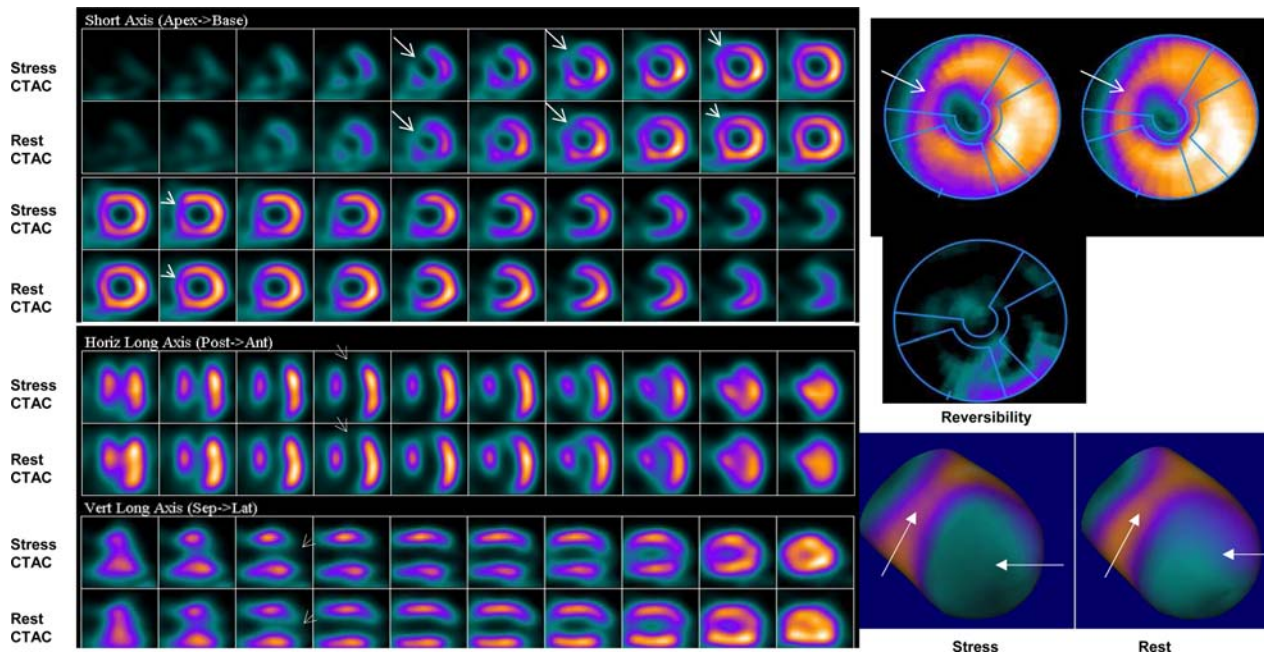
A 65-year-old male patient with a history of myocardial infarction underwent 99m-Tc MIBI MPS scan on Symbia T6 IQ•SPECT with treadmill (stress dose 7 mCi 99m-Tc MIBI followed by rest dose 22 mCi after 3 hours). Integrated low-dose CT was performed during free breathing and used for CT attenuation correction. The study shows a large fixed perfusion defect in the anterior wall, apex and septum related to previous infarction and a slight amount of reversible ischemia in the peri-infarct zone, distal septum and inferior wall. Stress and rest study were acquired in 4 minutes each. Images courtesy of Siemens Medical Solutions USA, Inc.; Molecular Imaging, Hoffman Estates, IL.
